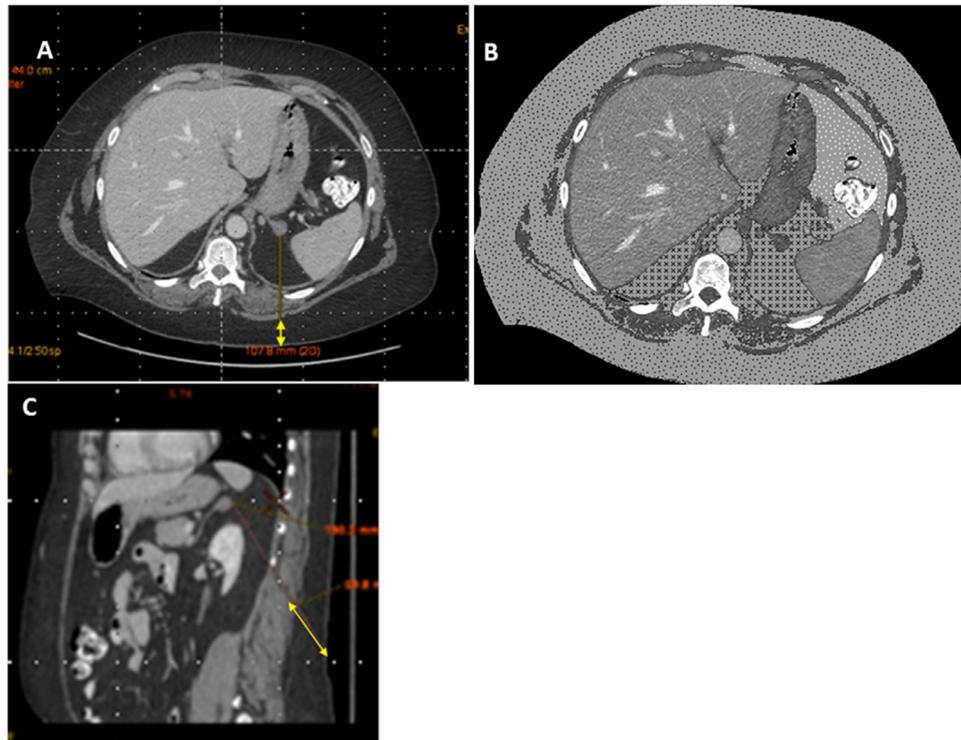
Graphic representation of computed tomography imaging used to calculate the following: (A) yellow arrow represents the axial distance of skin to muscle (cm), (B) CS retroperitoneal fat area (cm²), and (C) yellow arrow represents the sagittal distance of skin to muscle (cm).
